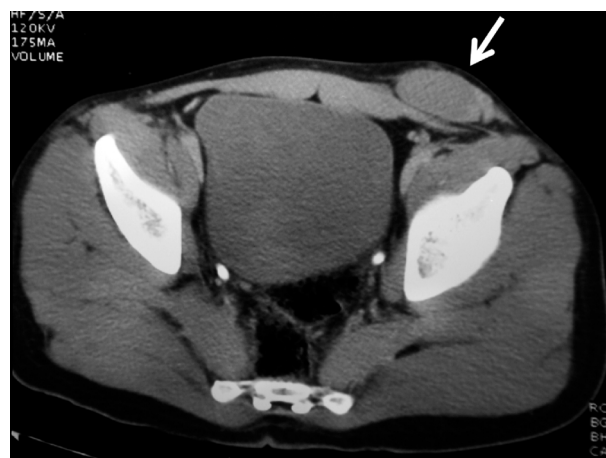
A slice of computed tomography presenting dislocated left testicle (arrow).
